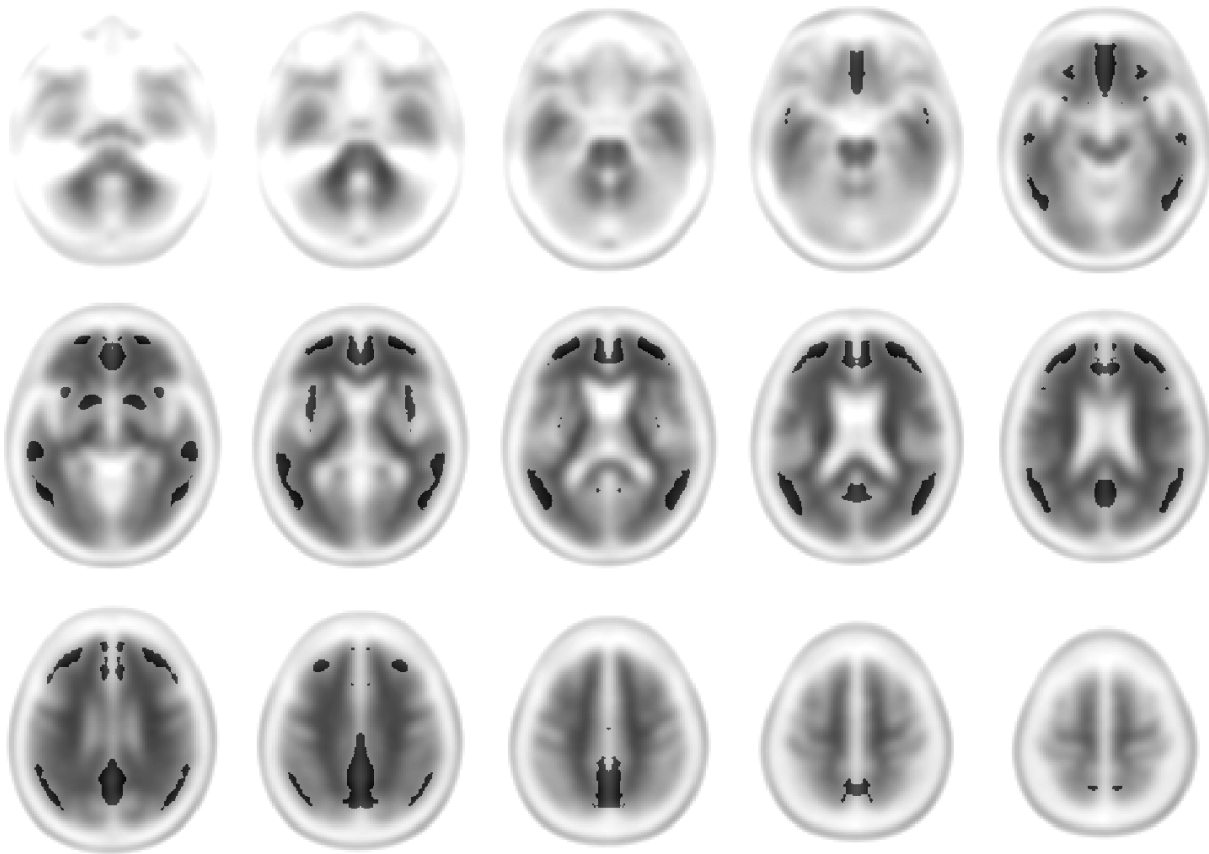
Uptake regions for the computation of SUVR values superimposed on the reference PET. The counts normalization region (not shown here) is the whole cerebellum.
